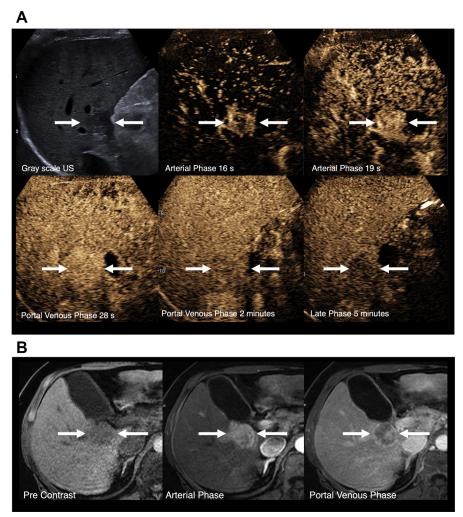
62-year-old woman with cirrhosis secondary to chronic hepatitis C viral infection and alcohol abuse. (*A*) Precontrast ultrasound and CEUS images show a 3.0 cm hypoechoic nodule in segment 5. The combination of size \geq 10 mm and major features (*arrows*: non rim APHE, late and mild washout at 5 minutes) indicates a CEUS LR-5 lesion (definite HCC). (*B*) Same observation on pre- and postcontrast MRI. The presence of nonrim APHE, washout appearance, capsule appearance (*arrows*), and \geq 20 mm are major features of definite HCC (LR-5).
